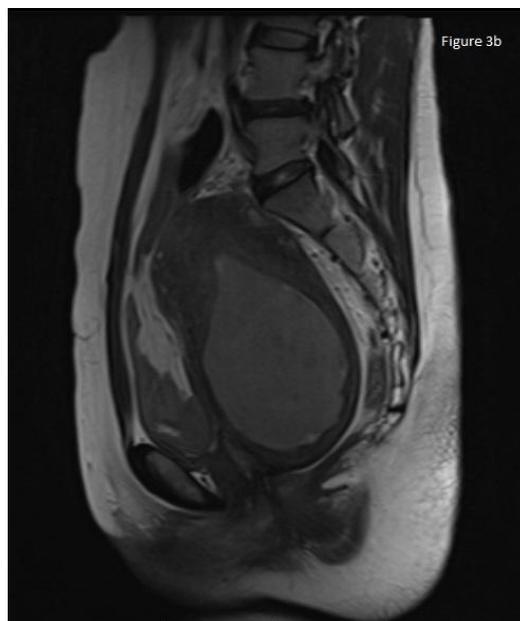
MRI Sagittal T2WI showing hematometra of intermediate signal intensity.
